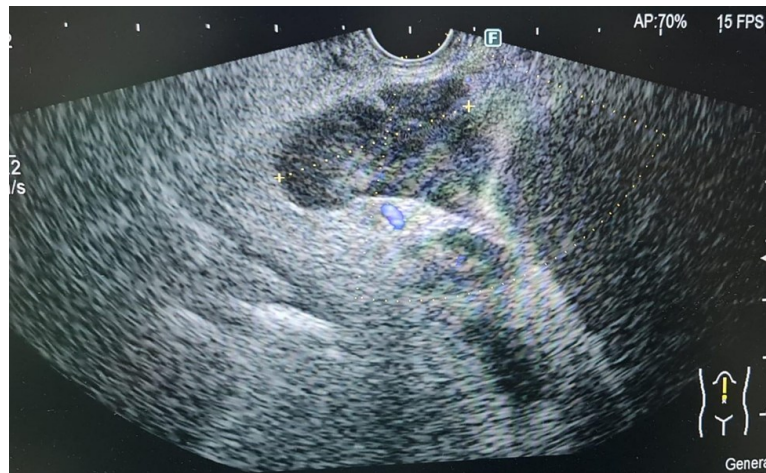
Endoscopic ultrasound showing enlarged peri-hepatic lymph node.
